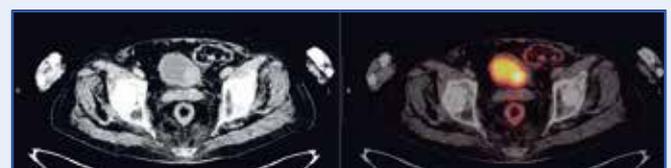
FDG PET CT displaying FDG avid thickening along the left posterolateral aspect of the urinary bladder, subsequently found to be the cause of hematuria (transitional cell carcinoma).
